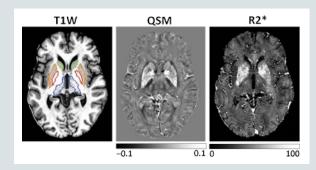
Images from a 2D cross-section of T1-weighted, quantitative susceptibility map (QSM) and R2* (1/T2*) of a healthy elderly female subject (72 years-old) at 7T (Acquired at the Center of Advanced Imaging, University of Queensland). Subcortical structures including globus pallidus (red), putamen (orange), caudate (green), and thalamus (blue) are enclosed by contours. Increased tissue iron level associated with neurodegeneration and aging has been reported particularly in the subcortical regions. The R2* and QSM MR modalities are the most sensitive surrogate marker for iron in brain tissue.
